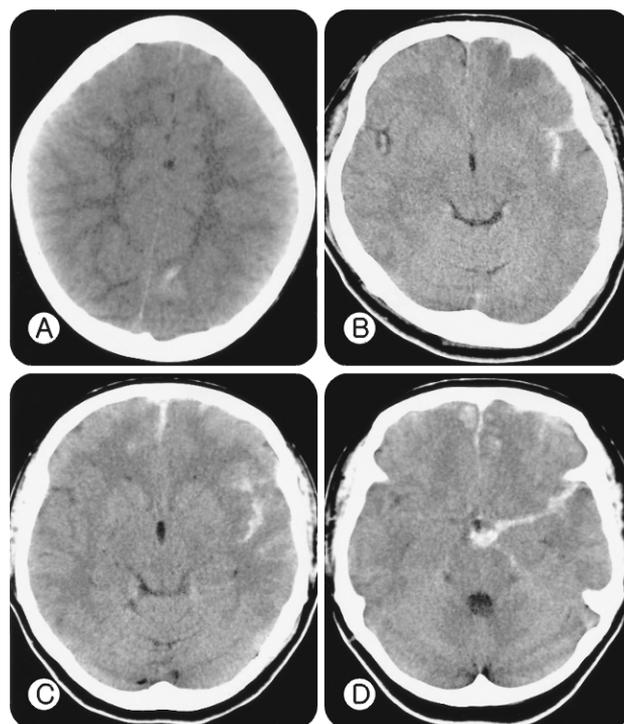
Morris-Marshall computed tomographic classification of Traumatic subarachnoid hemorrhage. (A) Grade 1—present only one location, (B) Grade 2—present at only one location, but quantity of blood fills that structure or is at any two sites, filling neither of them, (C) Grade 3—present at two sites, one of which is the tentorium filled with blood, (D) Grade 4—present at 3 or more sites, any quantity.
